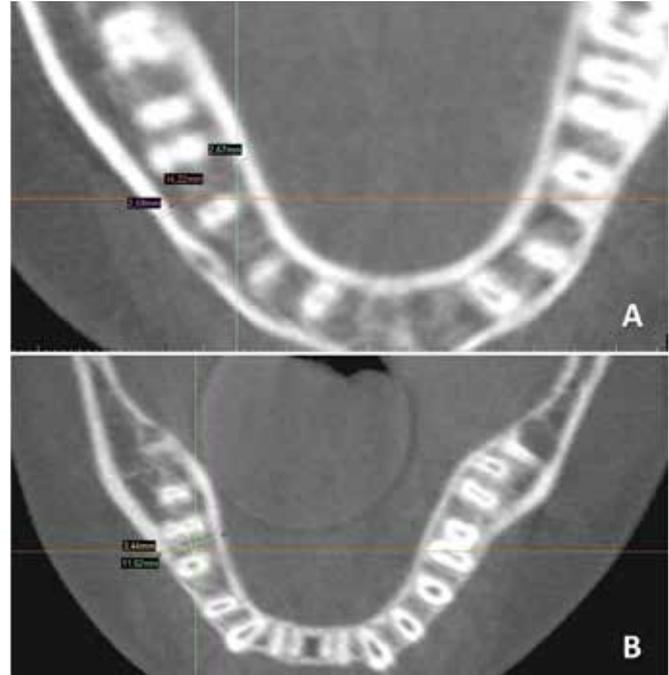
Measurements on the axial CT images of buccolingual distance, cortical bone thickness (A) and, interradicular space (B).
